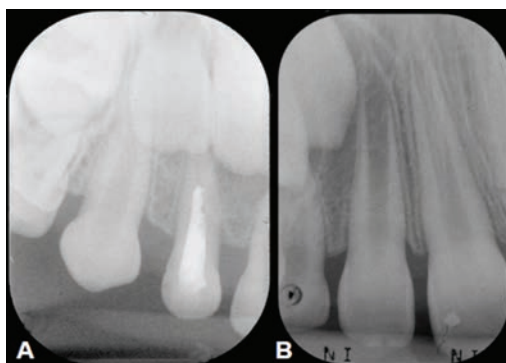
Radiographic performance of Pa2. A) Radiography performed immediately after root canal obturation and coronary restoration of primary maxillary right lateral incisor. B) After 29 months of treatment of primary maxillary right lateral incisor radiograph monitoring of the eruption of permanent maxillary right lateral incisor.
